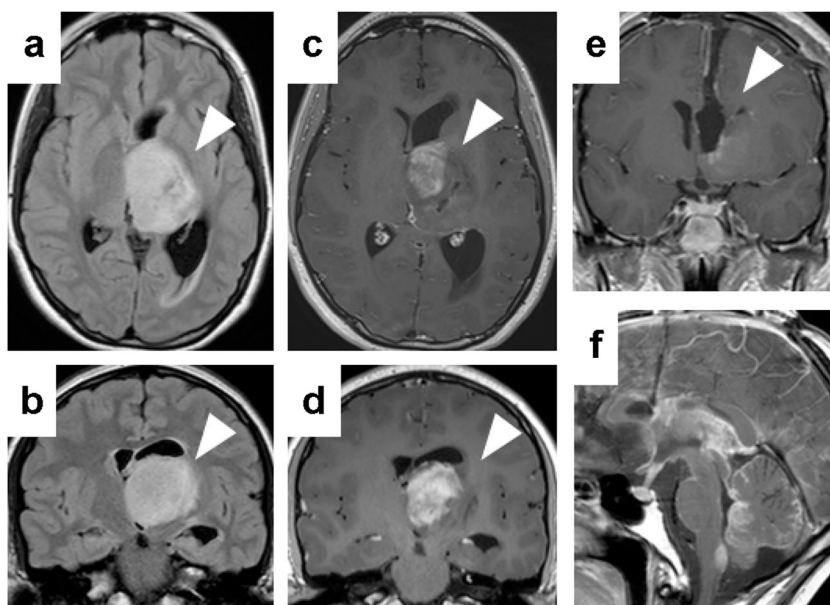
MRI at 1 year after stereotactic biopsy (a, b: FLAIR, c, d: Gd) showing marked enlargement and contrast enhancement effect of the tumor (arrowheads). Transcallosal tumor resection was carried out (e: Gd), and tumor dissemination to the subarachnoid space occurred 12 months after second surgery (f: Gd)
